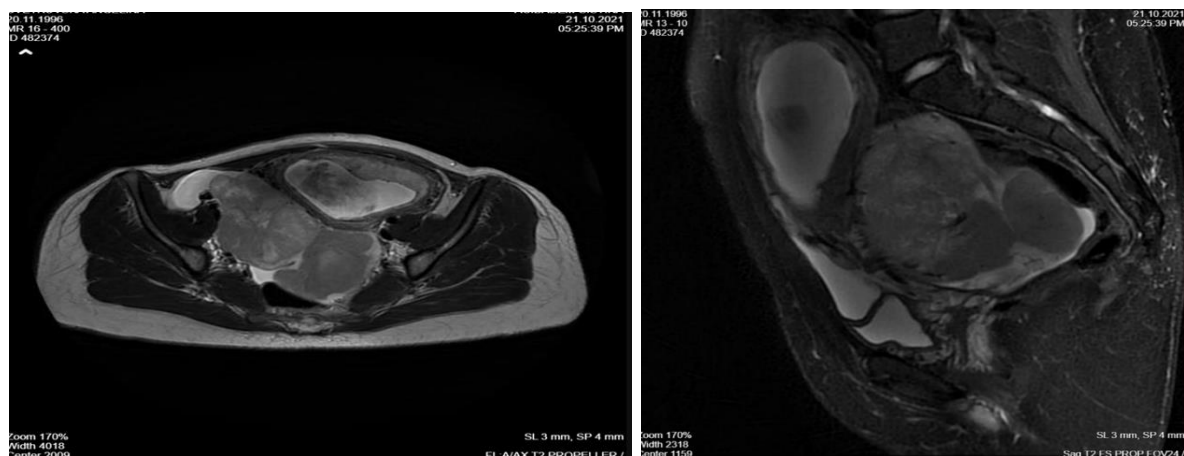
Non-enhanced MRI of pelvis sagittal view showing tumor mass behind the uterus
